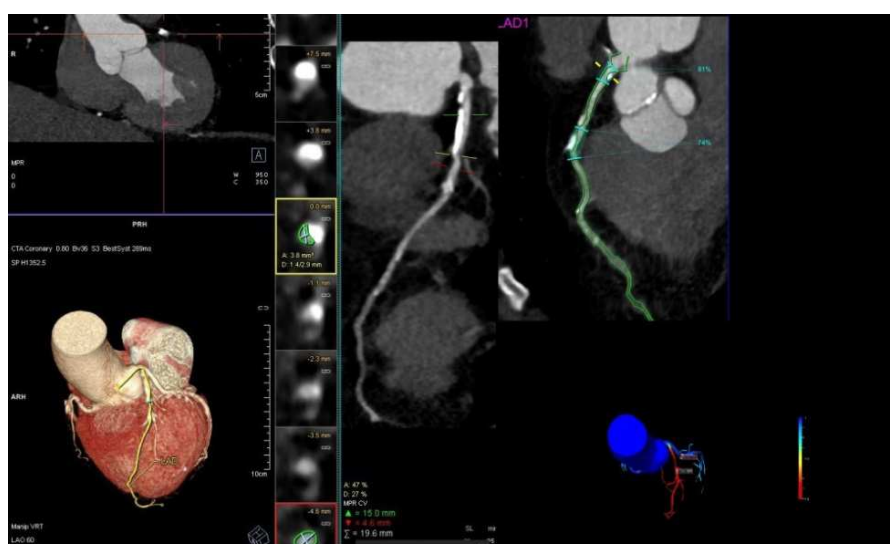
Showing 88% stenosis by cross section method and concordant 91% stenosis by AI method with reduced CT FFR in left anterior descending artery.
